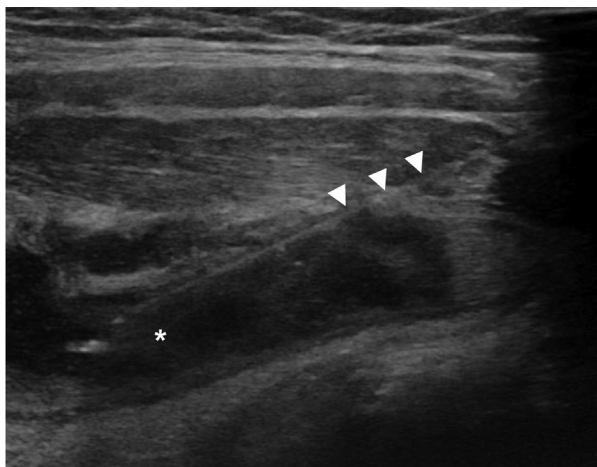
Ultrasound-guided needle aspiration of the abscess performed by a radiologist on day 3. It shows a needle (arrowheads) inserted into the fluid in a larger amount (asterisk) than in Figure 1.
